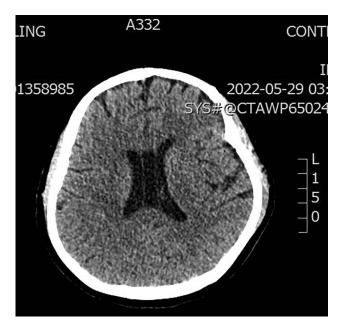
The brain CT displayed showed no sign of stroke.
